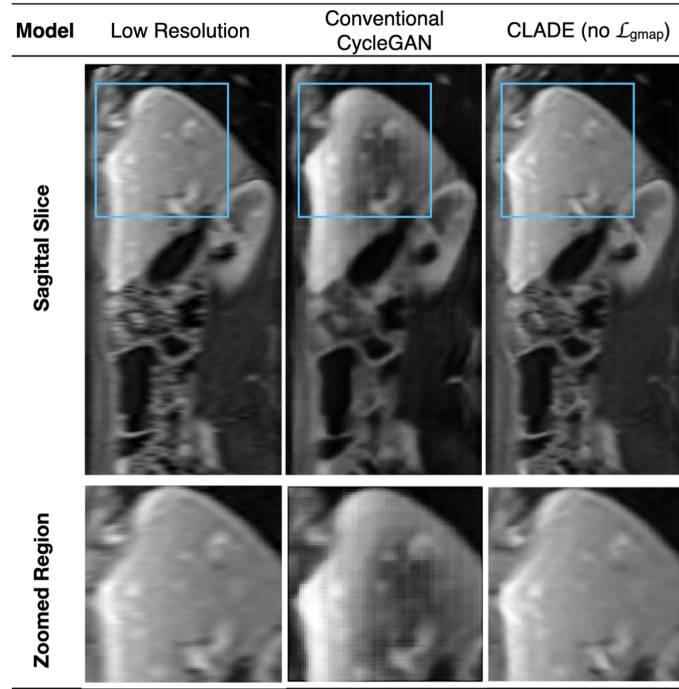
An example low-resolution sagittal MRI slice from one subject in the test data, which shows normalisation errors when SRR is applied using a Conventional CycleGAN. These artifacts are removed when SRR is applied using CLADE (no \mathcal{L}_{gmap}). Magnified regions within the blue box are displayed beneath each image.
